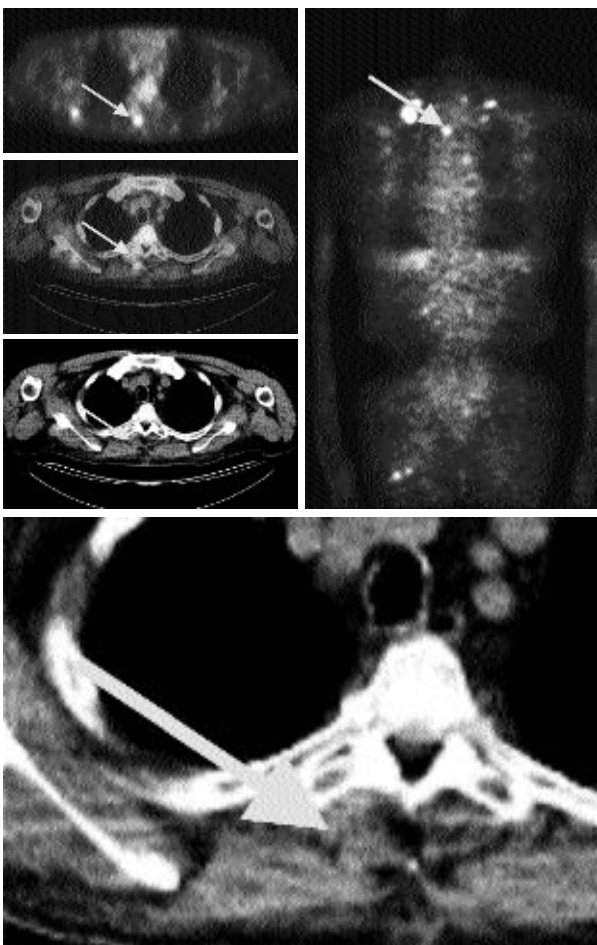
Soft tissue metastasis of malignant melanoma surrounded by muscle tissue and normal CT of this region.
